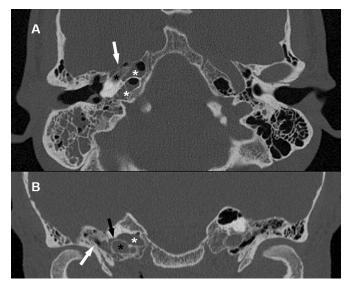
Computed tomography (axial [upper] and coronal [lower] views) demonstrating the pneumatized petrous apex cells filled with cerebrospinal fluid (white stars) communicating to the Eustachian tube (white arrows) through a small bony dehiscence (black arrow). Black stars in the upper and lower panels show the internal carotid artery.
